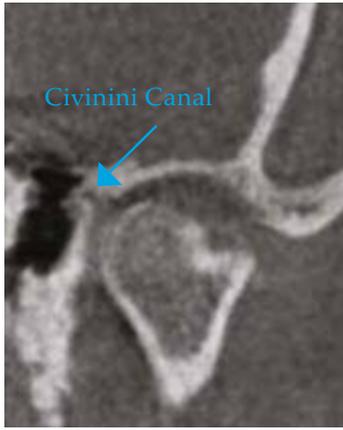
ATM CT scan where the Civinini Canal is highlighted, this connects the temporomandibular joint with the cavity tympanica
